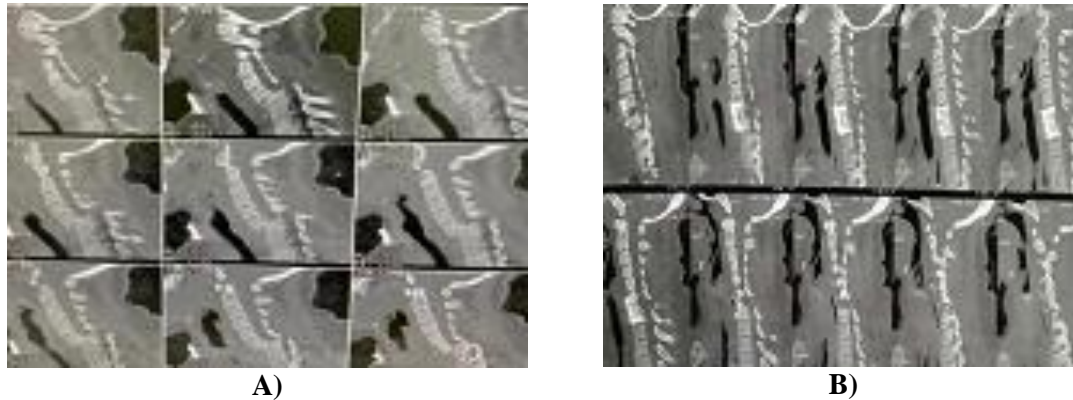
Preoperative MRI (A) and postoperative MRI (B) showing C6-7 dislocation.
